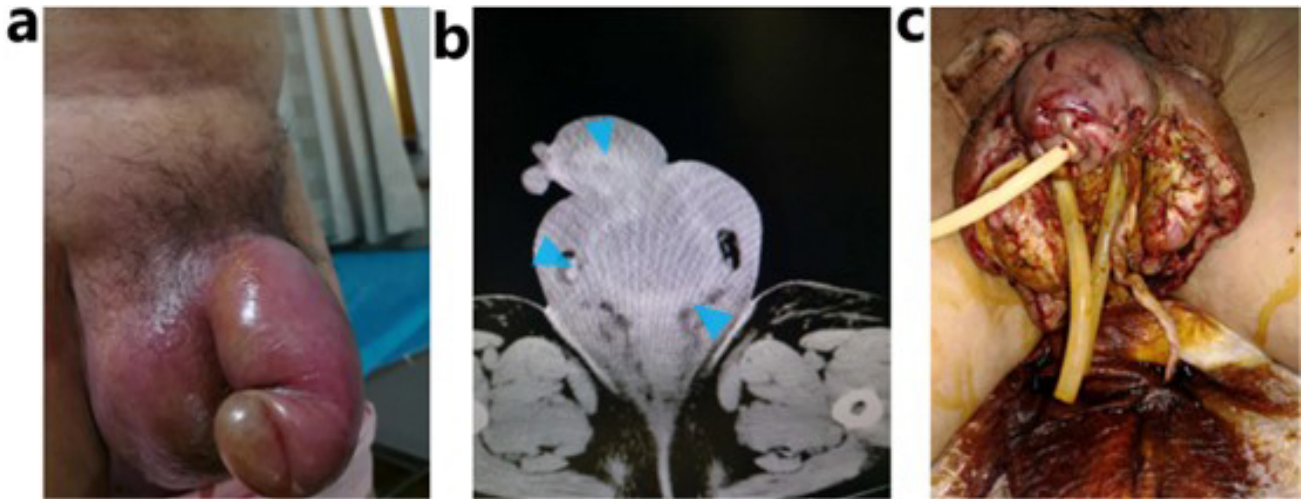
Physical and radiological images of the scrotum and the penis. (a) shows swollen, ulcerated, and oozing pus, (b) shows the computed tomography (CT) imaging, (blue arrows) shows the ulceration and the swollen parts, (c) presents multiple incisions were made for drainage.
